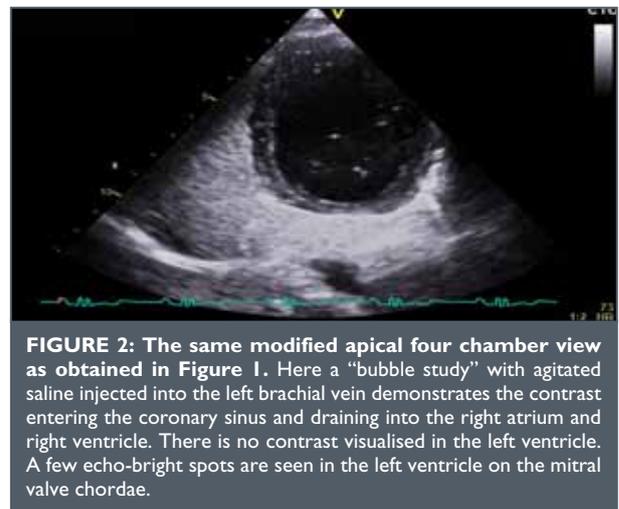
The same modified apical four chamber view as obtained in Figure 1. Here a “bubble study” with agitated saline injected into the left brachial vein demonstrates the contrast entering the coronary sinus and draining into the right atrium and right ventricle. There is no contrast visualised in the left ventricle. A few echo-bright spots are seen in the left ventricle on the mitral valve chordae.
